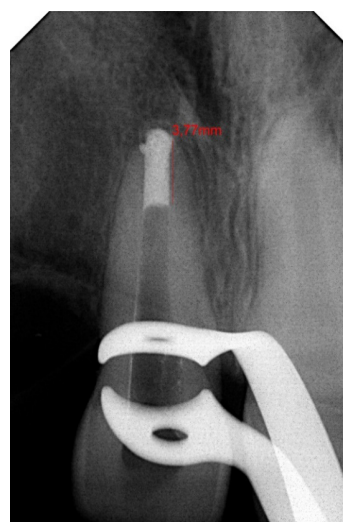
Targeted X-ray of tooth 11 (root canal apex obturated with Bio MTA+)
